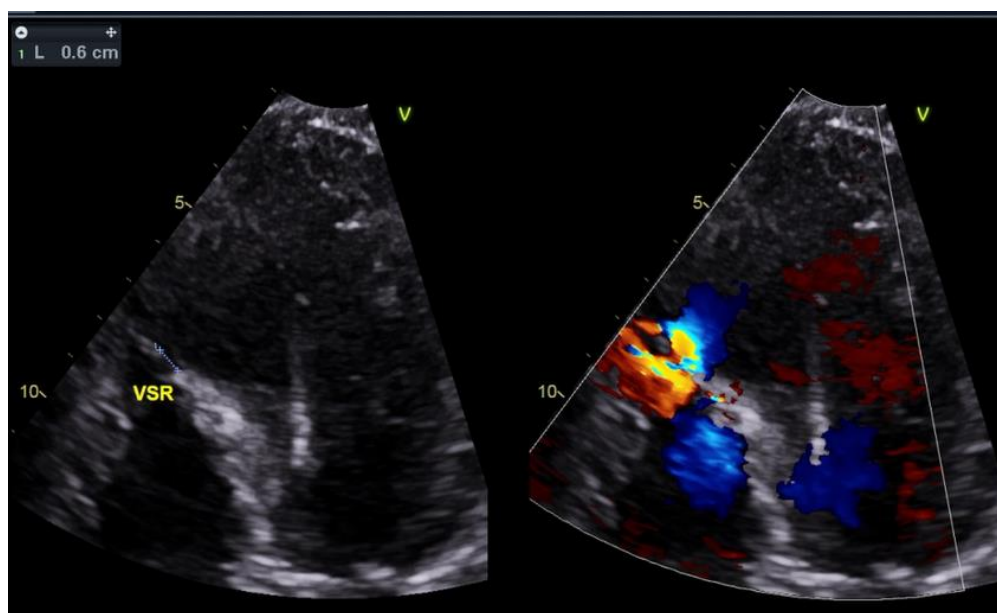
Echocardiography (apical 4-chamber view) showing VSR (0.6 cm) at apical septal segment
